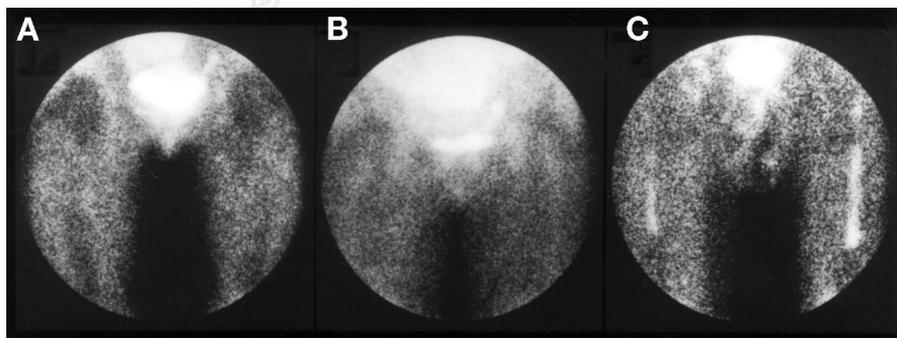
Classification of ^{99m}Tc -MIBI activity patterns. (A) No detectable activity in patient with breast cancer was confirmed by lack of abnormal MRI findings. (B) Homogeneous mild activity in patient with lung cancer was confirmed by lack of abnormal MRI findings. (C) Clearly visualized focal activity in patient with malignant lymphoma (non-Hodgkin's) was confirmed by abnormal MRI findings and bone marrow cytology from puncture sites on each anterior iliac crest. Clearly visualized activity of ^{99m}Tc -MIBI was interpreted as abnormal.
